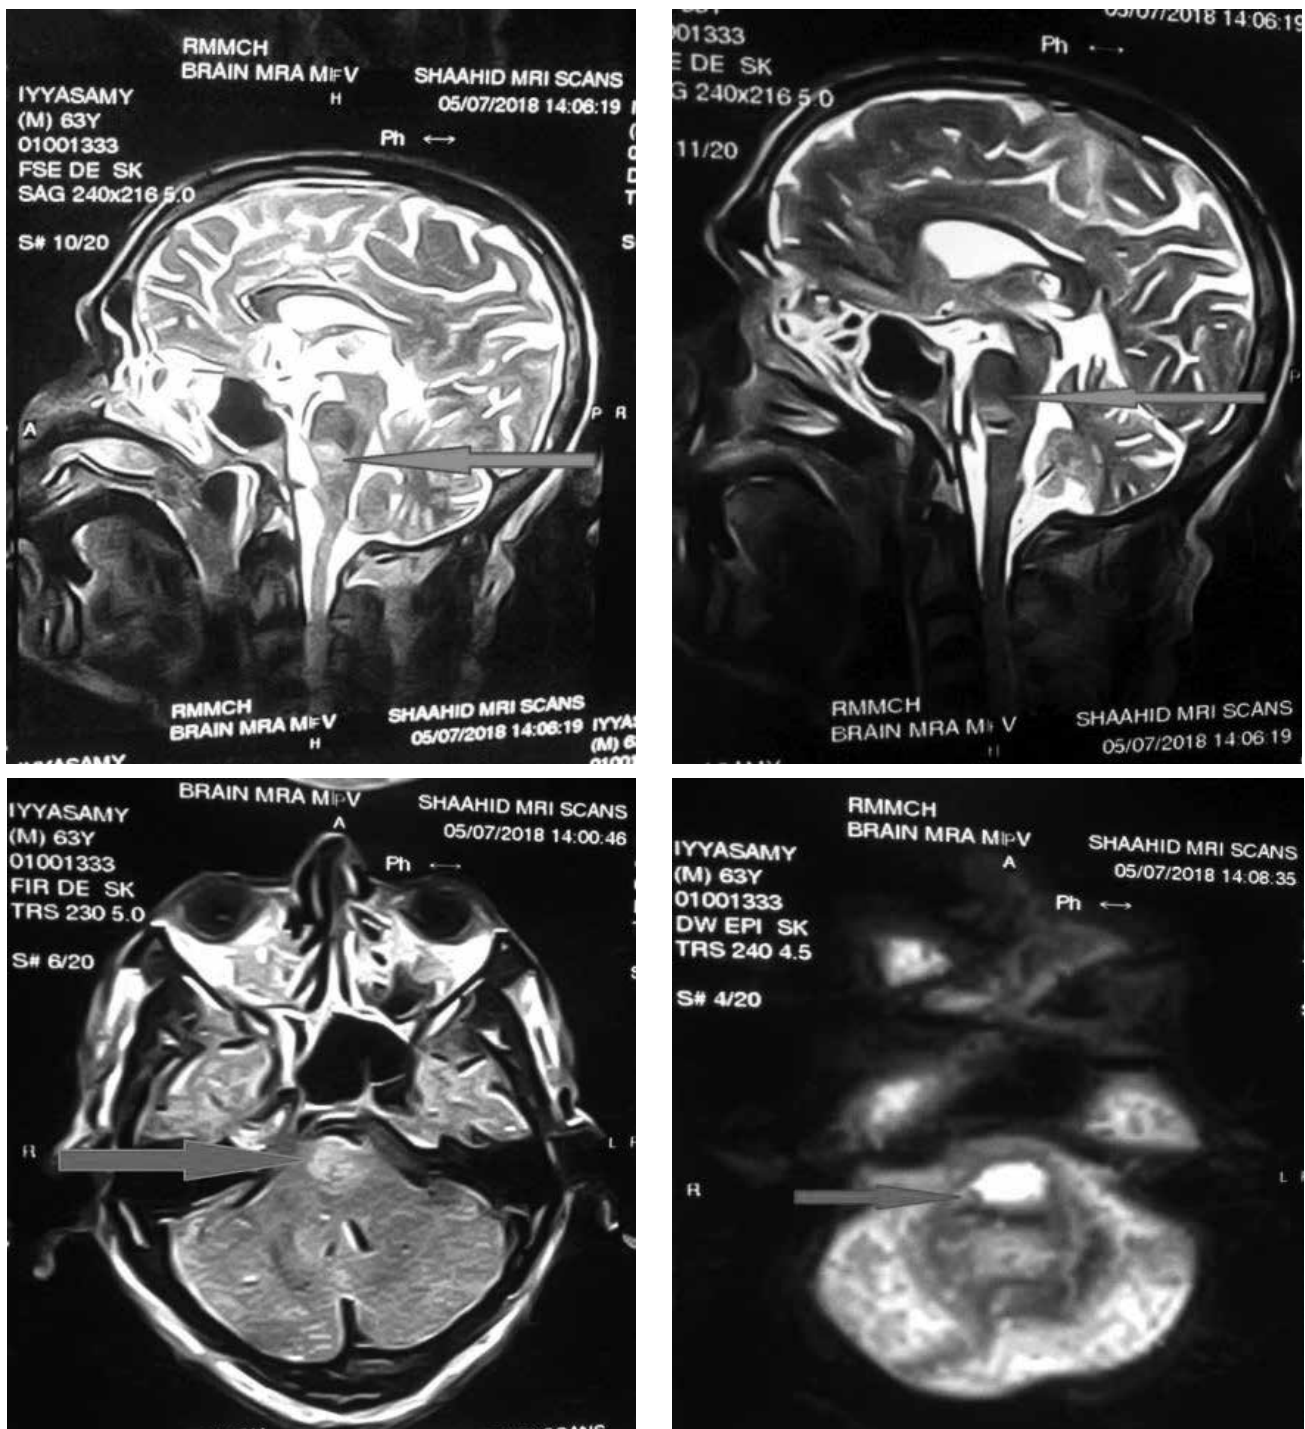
MRI brain image showing well-defined area of diffusion restriction in lower central pons bilaterally.
